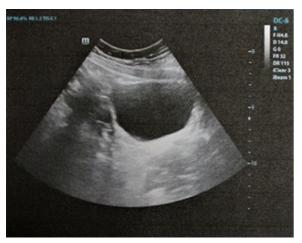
Ultrasound image of Patient with MRKH showing normal abdominal viscera but absent uterus and cervix
